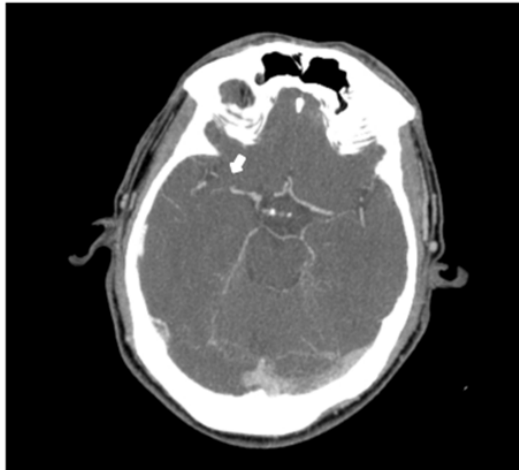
Head angiography CT showing an occlusive blood clot on the M2 segment of left middle cerebral artery with no signs of cerebral ischaemia.
